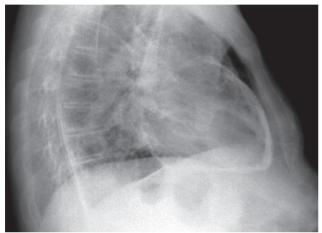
Calcification of the pericardium on chest x-ray (lateral view)
